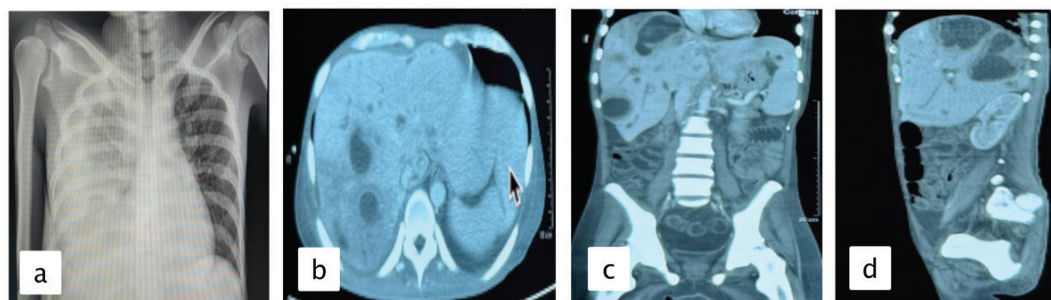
(a) Chest Radiograph Demonstrating Right Pleural Effusion. (b-d) Axial, Coronal, and Sagittal MSCT Images Demonstrating Multiple Hepatic Abscesses
